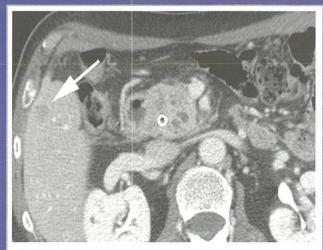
Contrast-enhanced portal venous phase CT scan demonstrates a metastatic lesion in the liver (arrow).
